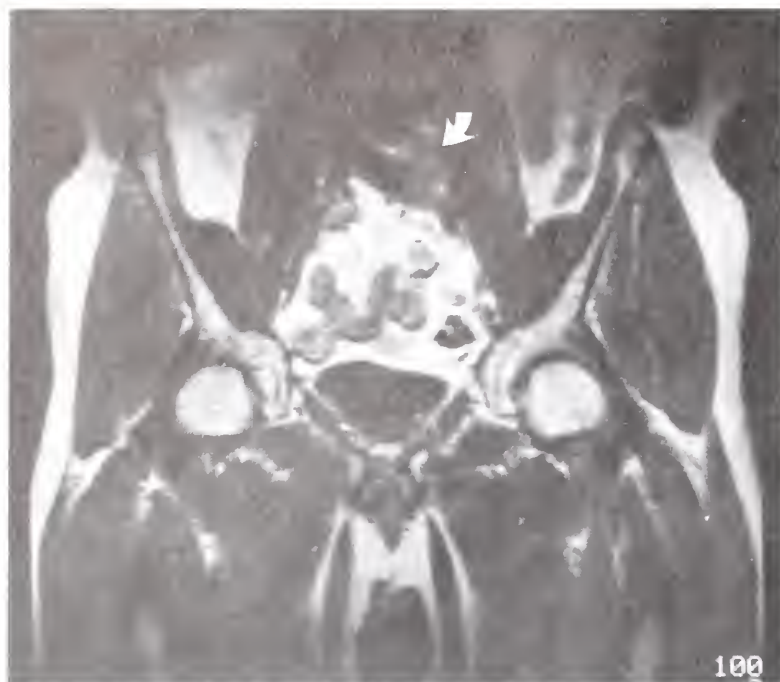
Stage D1 prostate carcinoma. Bilaterally enlarged lymph nodes (*curved arrow*) are identified. However, it is only the size of the node (1 to 1.5 cm in length) that can be detected on magnetic resonance imaging, which cannot distinguish malignant from hyperplastic nodes; biopsy is essential.
